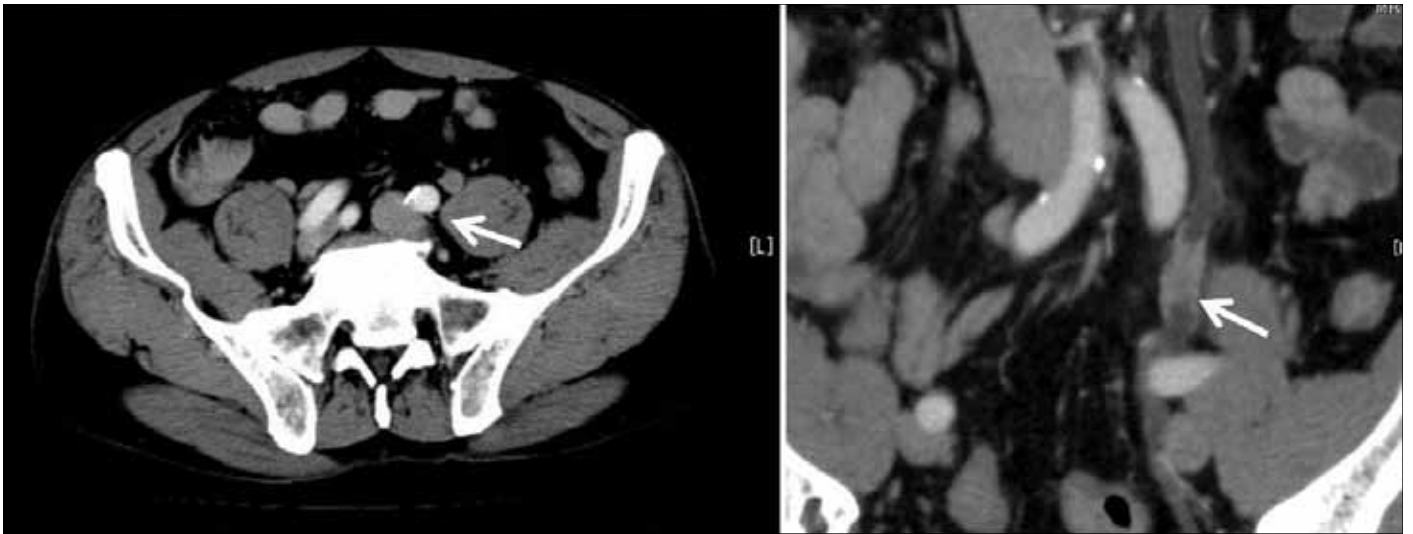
Computed tomography showing a 26-mm tumour (arrows) in the middle portion of the left ureter and left hydroureter.
